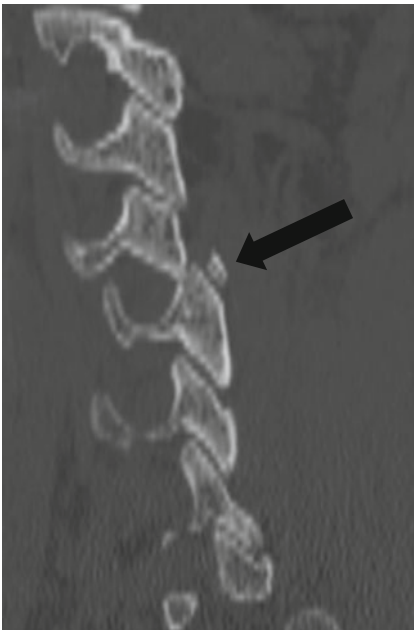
Arrow points to cervical facet dislocation—CT scan. Courtesy of Dr. John Houten
